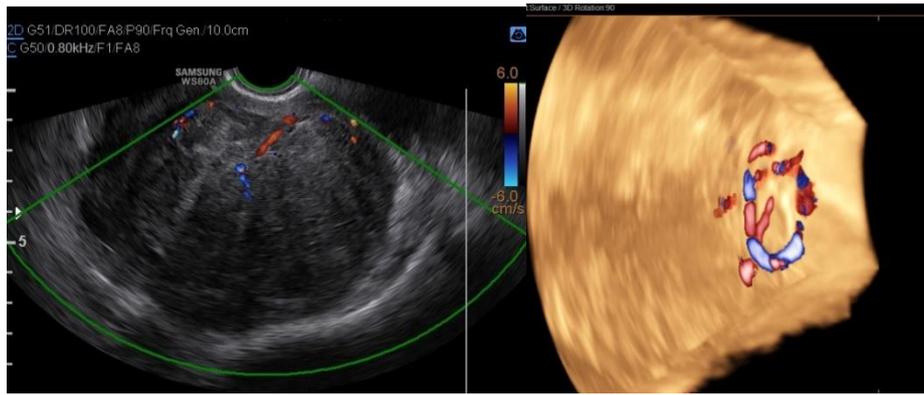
Transvaginal imaging of an oval-shaped uterine leiomyoma with mixed echogenicity and scant peripheral vascularity seen on color Doppler (A) and concentric blood vessels three-dimensional color Doppler image (B)
